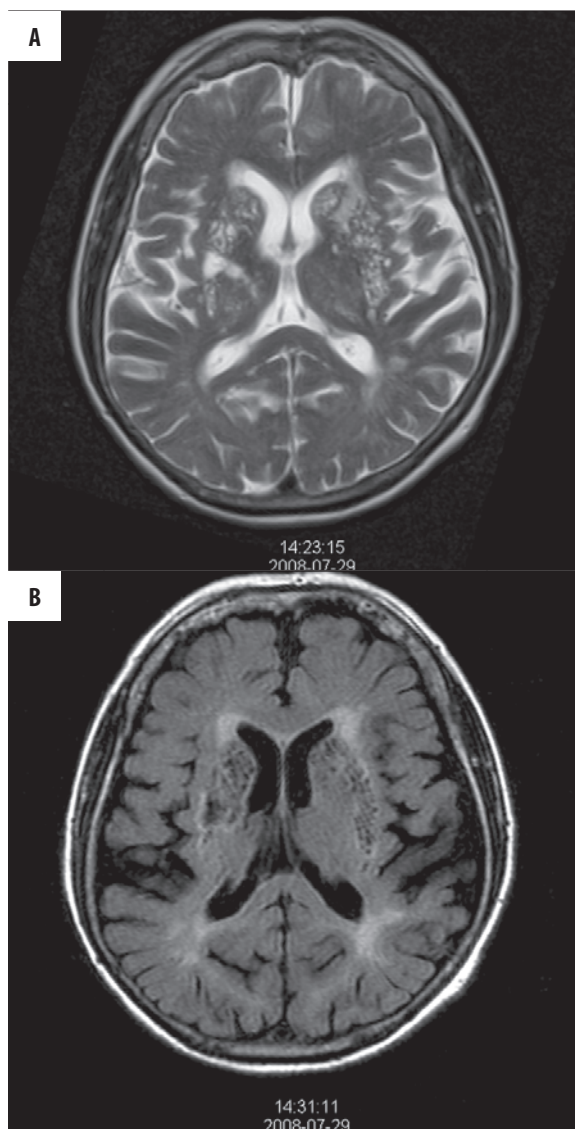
État criblé* – multiple dilated perivascular spaces in the basal ganglia in T2-weighted image (A). In FLAIR image (B) hyperintense periventricular vascular infarction lesions are also seen.
